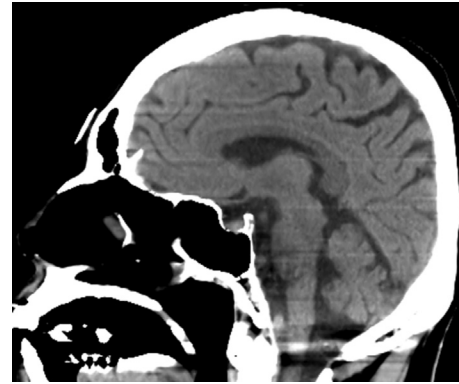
Brain computed tomography showed no abnormal findings.
